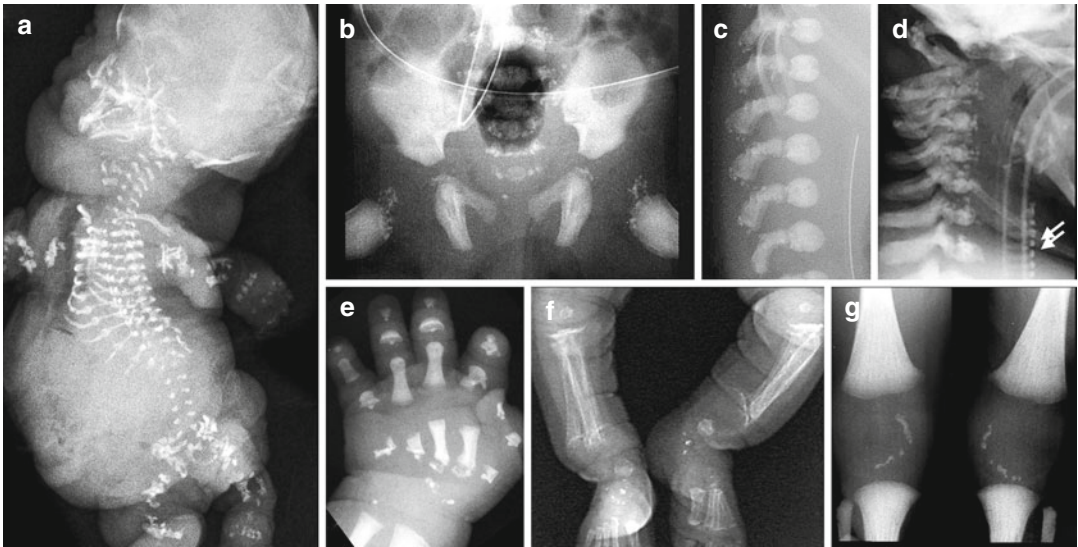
Examples of “stipplings” (punctate calcifications) in different disorders. (a) Fetus with Greenberg dysplasia (recessive mutations in the lamin B receptor gene (*LBR*) that also has 3-beta-hydroxysterol delta(14)-reductase activity) with generalized punctate calcifications in cartilage elements leading to growth disruption and lethal chondrodysplasia; (b–d) radiographs of a newborn with X-linked brachytelephalangic chondrodysplasia punctata (arylsulfatase E deficiency (*ARSE*)) showing much more discrete stipplings at the proximal femurs, at the ilio-ischiadic junction at around the spine; however, note (in d) severe hypoplasia of cervical vertebrae (leading to instability) and calcification of the tracheal rings
